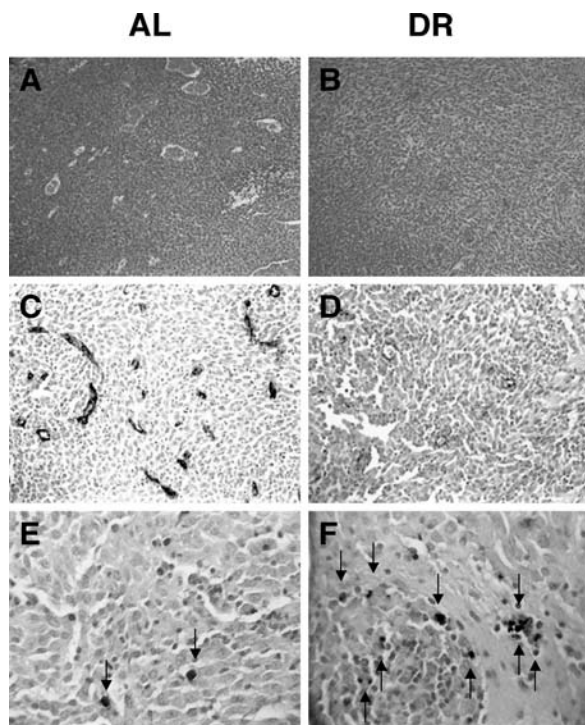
Influence of DR on microvessel density and apoptosis in the CT-2A brain tumour. DR was initiated 7
